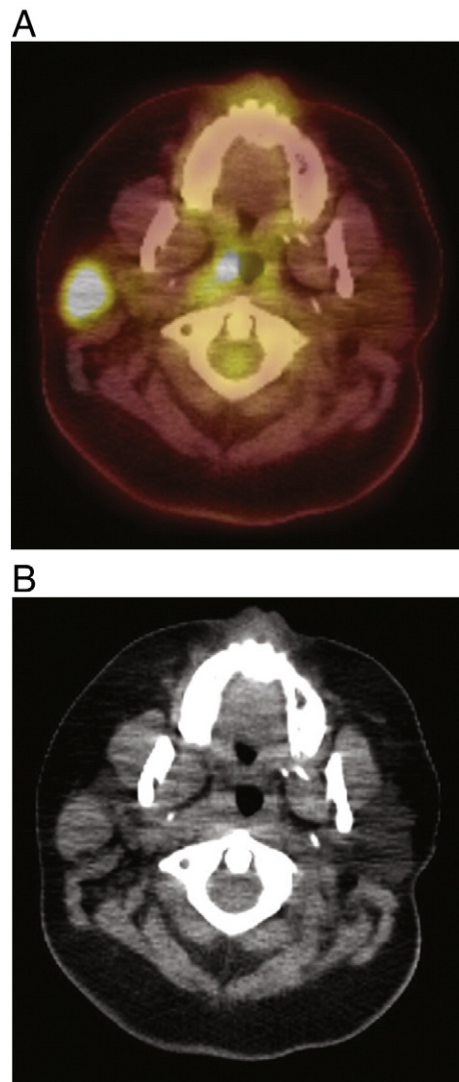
Positron emission tomography/computed tomography of the neck (PET/CT). A, There is a right neck mass posterior to the right parotid and bilateral cervical adenopathy. B, There is avid FDG uptake in the right neck mass and focally in the right nasopharynx on PET/CT scan.
